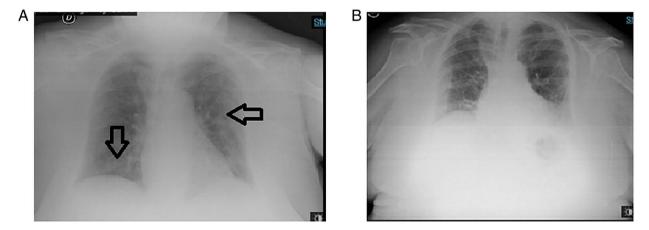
Chest X-ray results of the third patient in the present case series at (A) the time of admission and (B) upon improvement/discharge. Arrows indicate pathogenic lesions.
